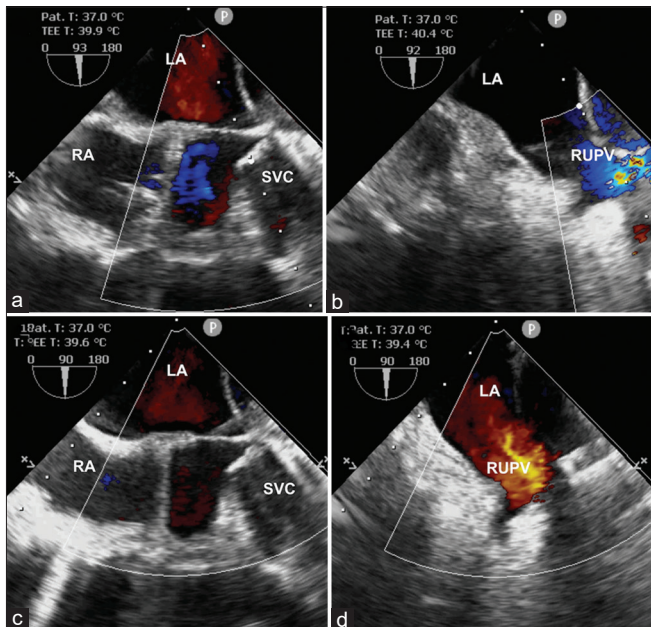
Bicaval view of transesophageal echocardiogram (a) following covered stent implantation in the superior vena cava (SVC) shows blue flows on color Doppler from the left atrium (LA) to the right atrium indicating residual shunt. The right upper pulmonary vein (RUPV) shows blue color flows (b), indicating flow directed toward the SVC. After deploying a second overlapping stent, the left-to-right shunt disappears (c), and RUPV flows (d) are red, directed toward the LA. RUPV: Right upper pulmonary vein, SVC: Superior vena cava, RA: Right atrium, LA: Left atrium
